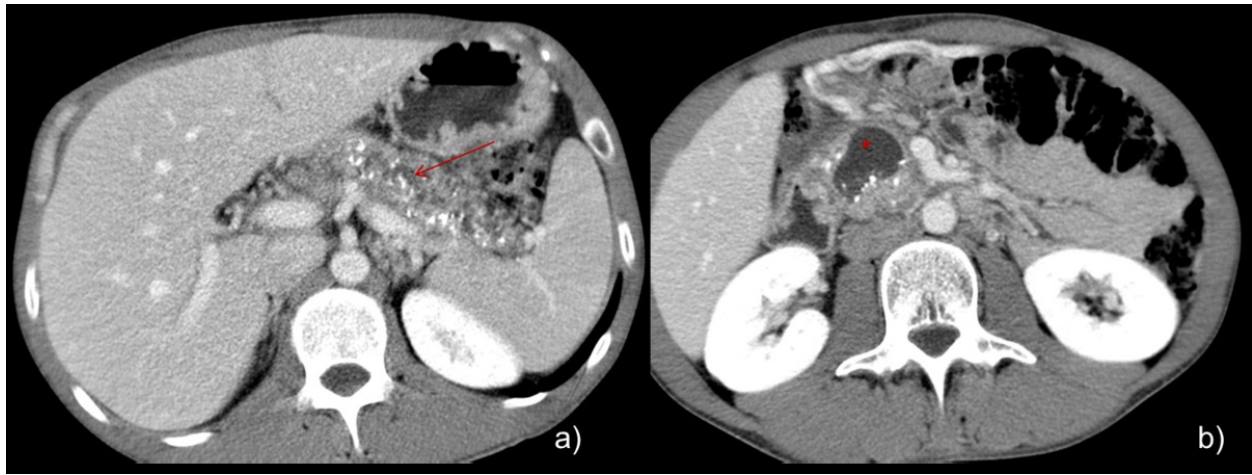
a) e b) - Enhanced axial CT portal venous phase images showing irregular main pancreatic duct dilatation (arrow), with diffuse intraductal e parenchymatous calcifications. At the level head a pseudocyst is seen (*).
